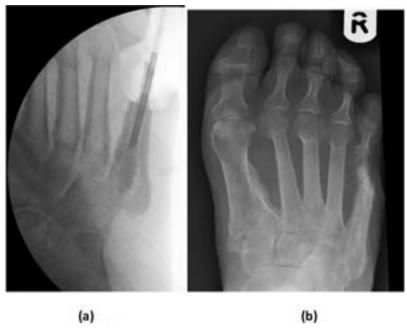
(a-b) Intraoperative radiographs of application of Cerament G at the 5th Metatarsal and radiography after 2 months.
